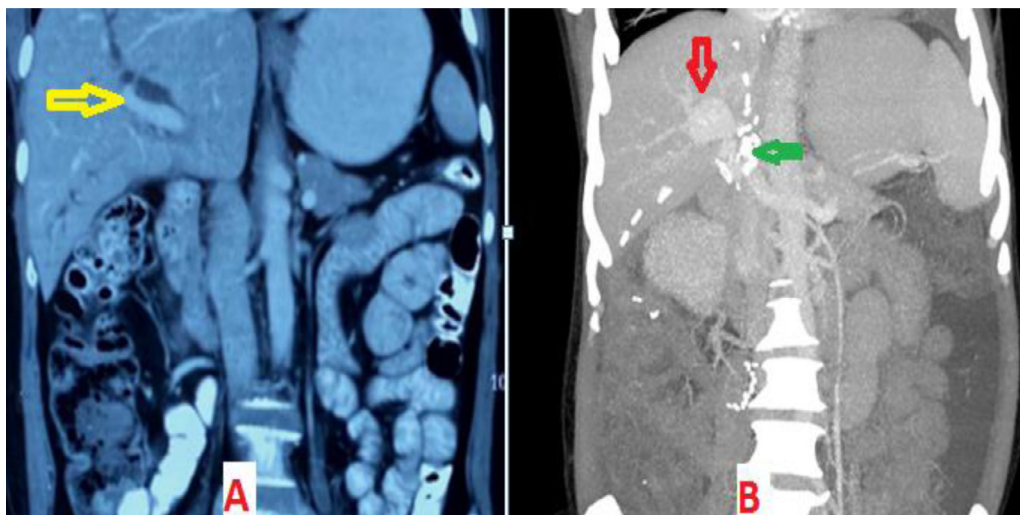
Case 2- Comparison of the portal vein status before and after surgery. IMAGE A (Before surgery)- CT abdomen (sagittal section) depicting a normal portal vein (yellow arrow). IMAGE B (postsurgery)- CT abdomen (sagittal MIP section) depicted a portal vein aneurysm (red arrow) and the surgical clips (green arrow).
